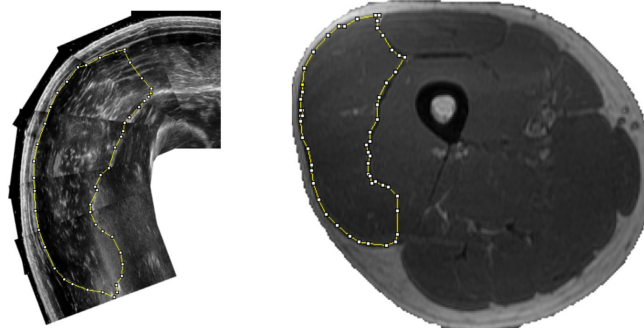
Representative images of vastus lateralis CSA (VLCSA) obtained from (a) B-mode ultrasonography, and (b) Magnetic resonance. VLCSA was manually outlined in both images using open-source (ImageJ) software by the investigators in a randomized and blinded manner
